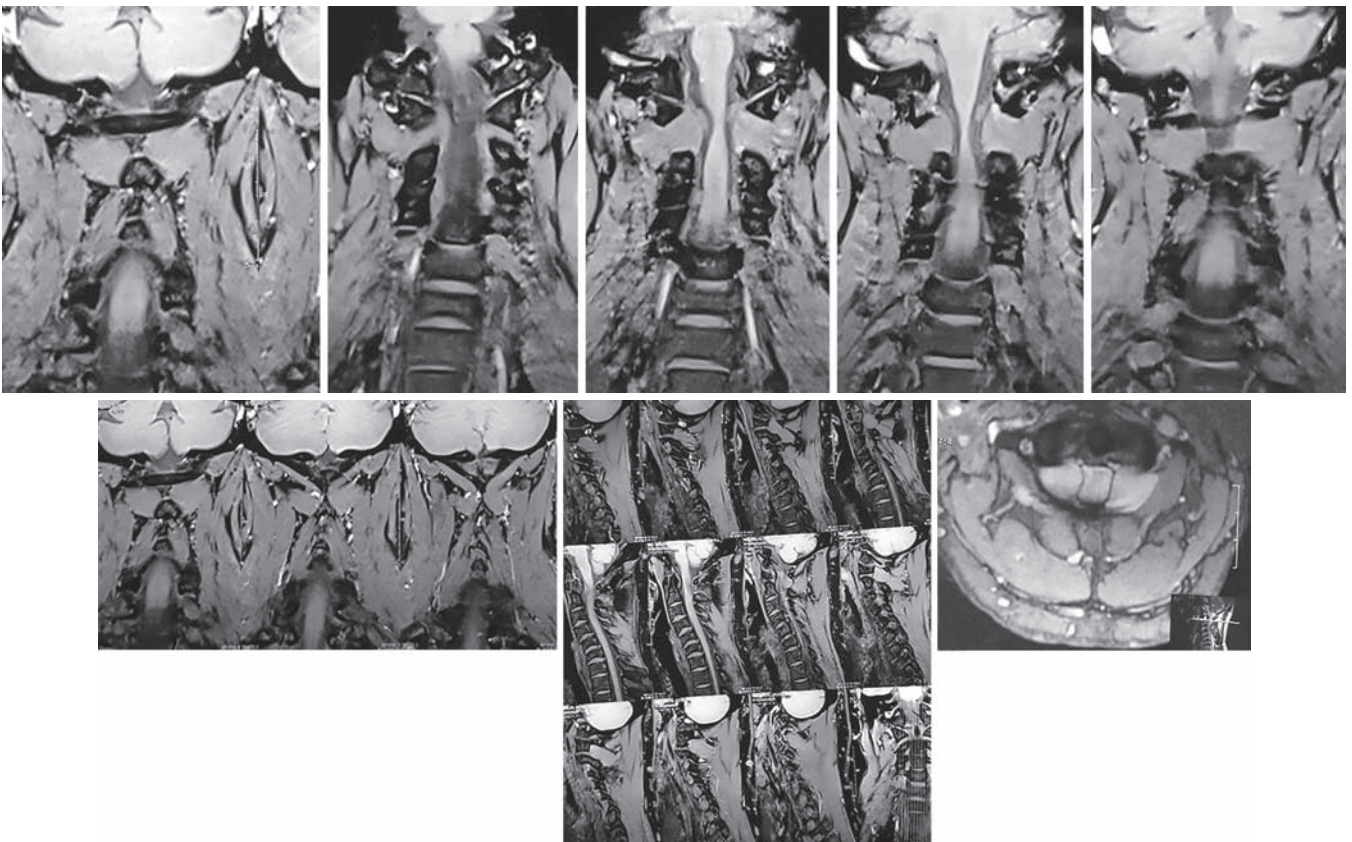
Coronal sagittal and axial MRI image of cervical region showing severe spinal cord compression bilaterally at C1-C2 junction (preoperative image)
